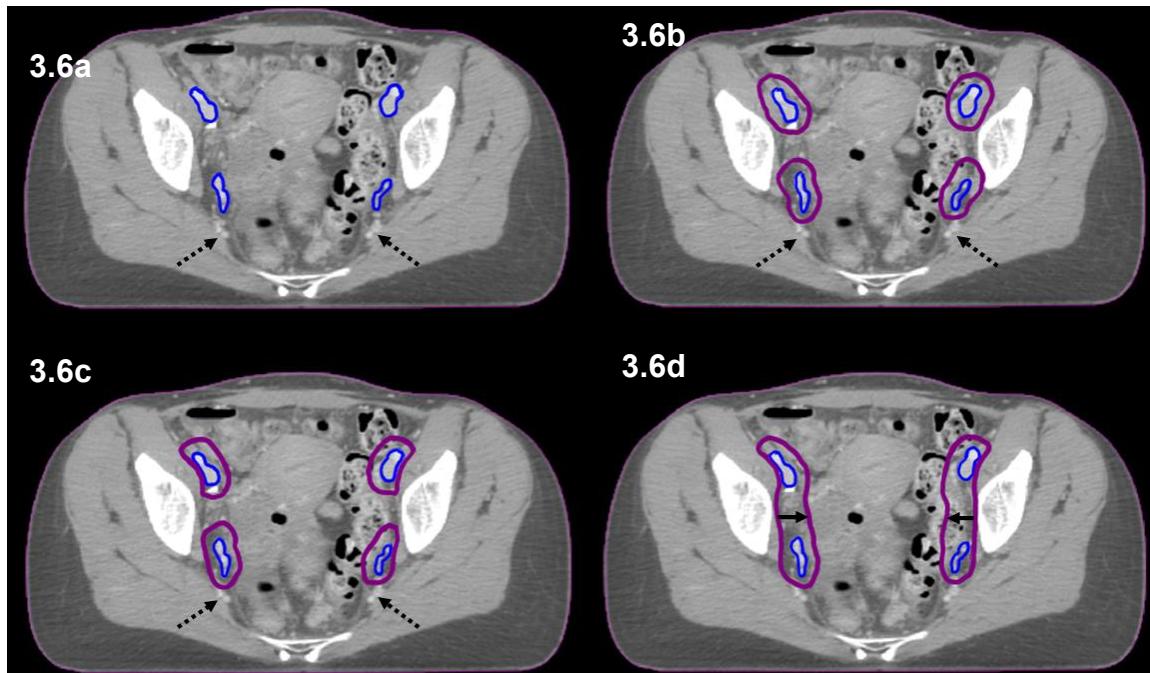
(a) Axial CT at distal level of internal and external iliac vessels (blue). (b) 7mm margin added (purple). (c) edited to exclude muscle and bone. (d) 18mm strip added (solid arrows) to cover obturator/infra-iliac nodal region. Gluteal vessels (dashed arrows) not to be included
